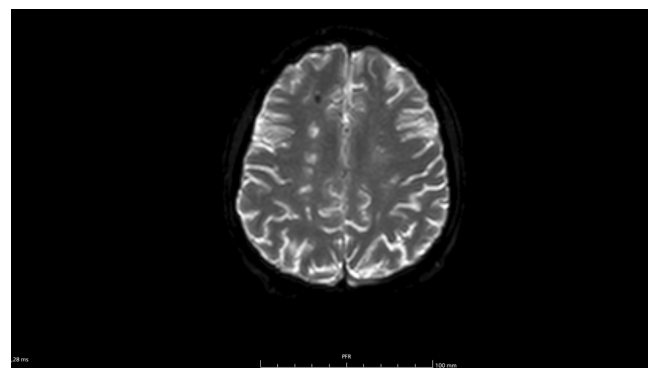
Contrast-enhanced encephalic MRI—DWI sequence demonstrating parieto-occipital cerebral cortex embolic-based ischemic lesions.
